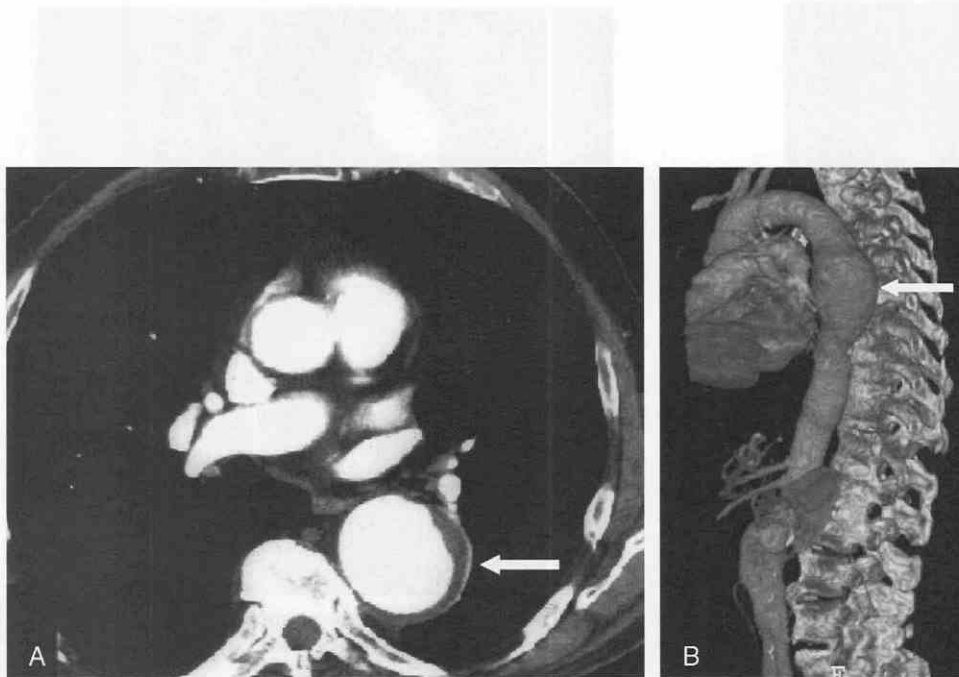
A, Axial CT scan shows dilatation of the descending aorta with surrounding thrombus (arrow). B, Sagittal oblique volume-rendered CT scan demonstrates fusiform aneurysm of the descending aorta (arrow).
